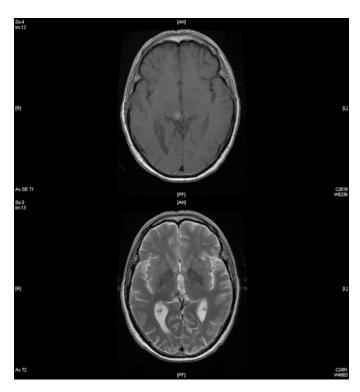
T1 and T2 weighted magnetic resonance imaging scan showing focus of right paramedian thalamic hemorrhage.
